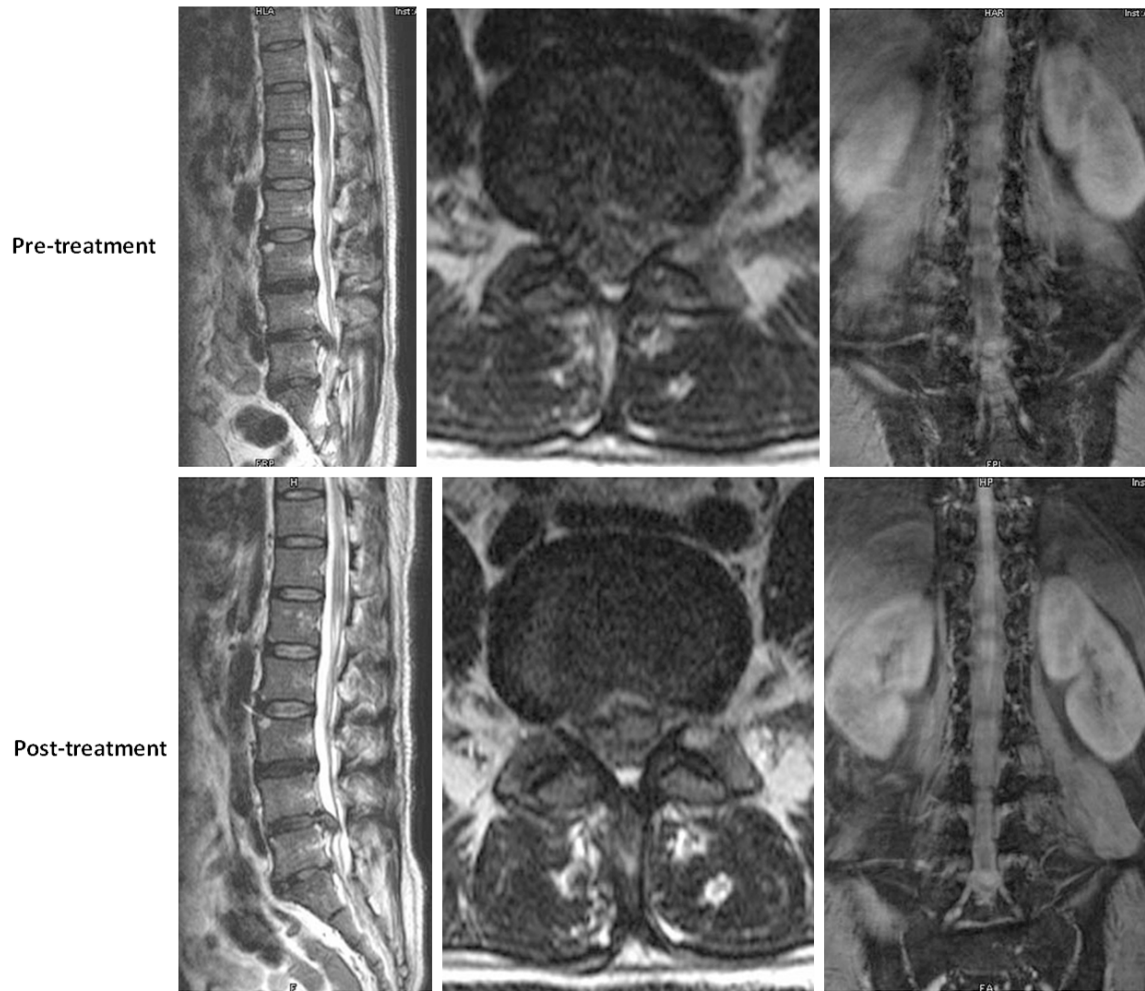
MRI of the patient pre-treatment and post-treatment. Magnetic resonance images showing L4-5 lumbar disc with 10 mm sequestered protrusion before treatment (the first three pictures), and no significant changes occurred after treatment (the latter three pictures).
